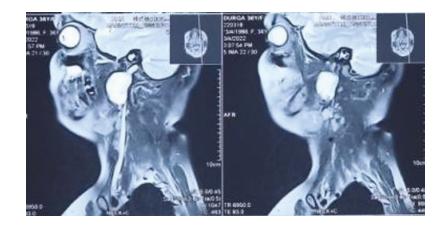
MRI imaging: axial cuts showing a lesion present in the left parapharyngeal space
